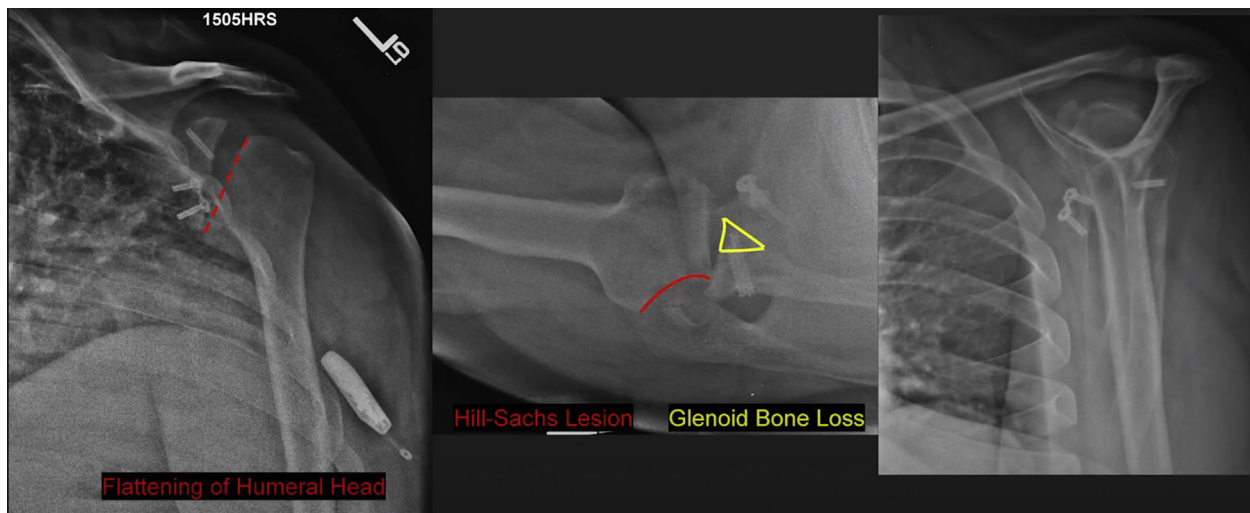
Post Latarjet x-ray films demonstrating failed Latarjet after subsequent seizure-induced dislocation resulting in fracture through the screws.
